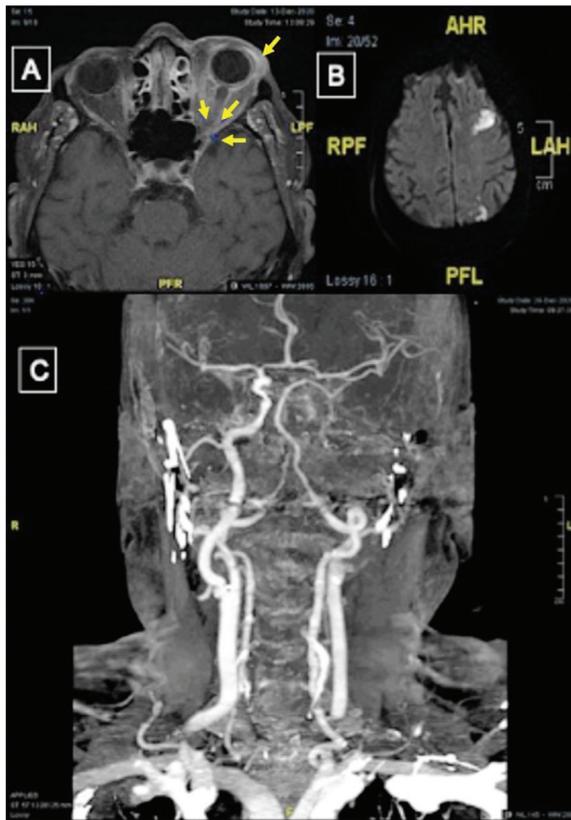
A) Preseptal and postseptal inflammation and prominent optic nerve edema in patient 3 at presentation are marked with arrows on orbital magnetic resonance imaging (MRI). B) On the ninth day of hospitalization newly developed distinct diffusion-restricting areas suggesting acute-subacute infarction were observed in the left frontal and parietal lobes on cranial MRI. C) Computed tomography angiography shows complete occlusion of left internal carotid artery on after the onset of right hemiparesis
